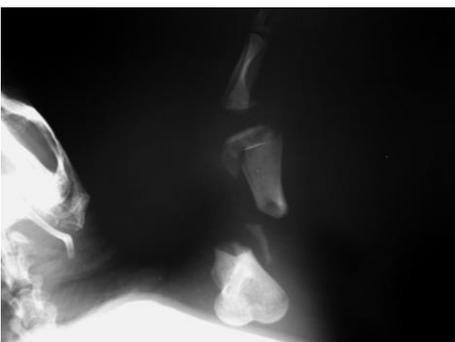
(a) Severe carapace damage caused by impact with a boat. The radiographic exam in craniocaudal (b) projection shows a deep fracture of the second and third vertebral shield close to neural bones. The radiograph in lateral view (c) projection shows the involvement of the spine.
